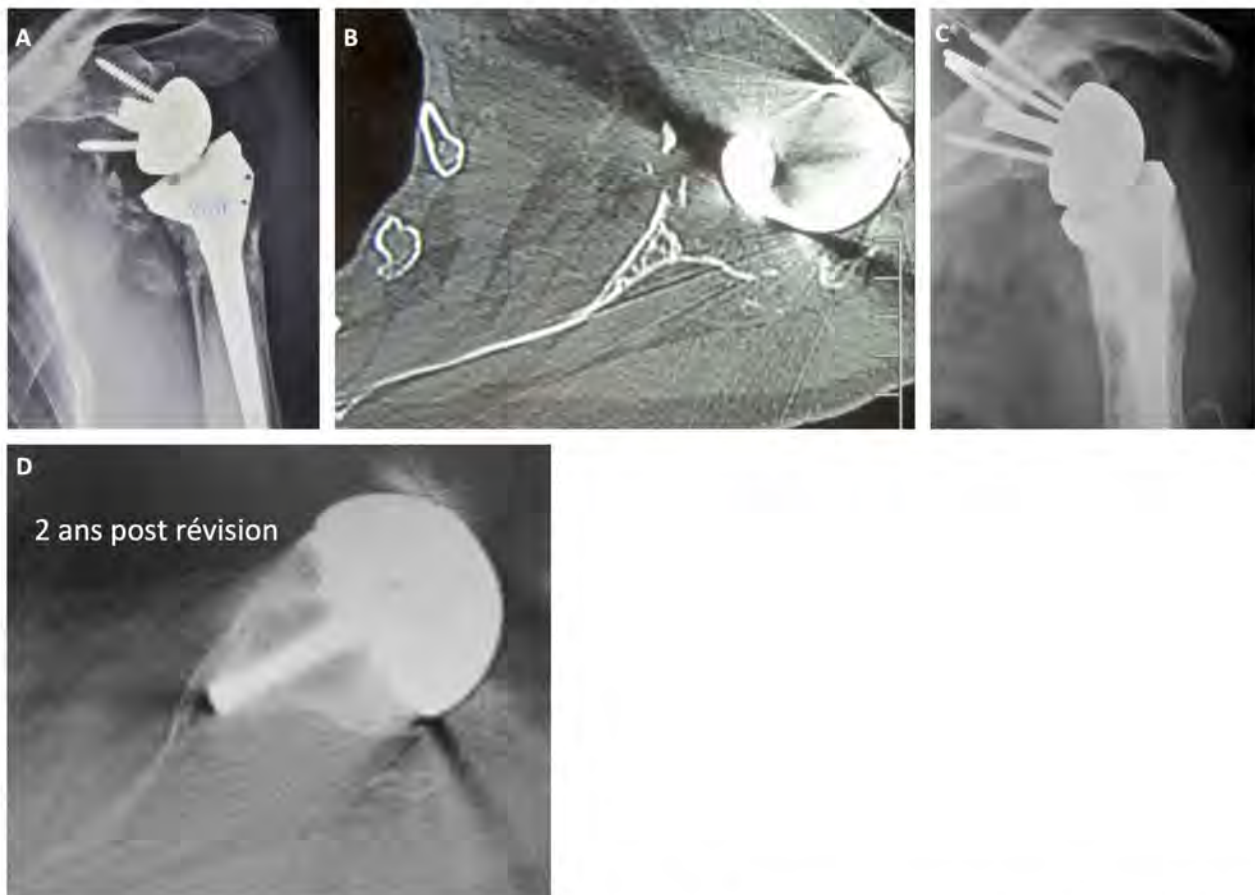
Example of aseptic glenoid loosening 7 years after RSA. A. Glenoid implant too high, with severe glenoid bone loss, humeral loss (3 cm) because of tuberosity resorption. B. Preoperative CT, showing complex glenoid bone defect. C. Reconstruction by iliac tricortical graft with long-peg (30 mm) glenoid component; proximal humeral reconstruction by cement. D. Postoperative CT: reconstituted glenoid bone stock and perfect glenoid graft consolidation.
